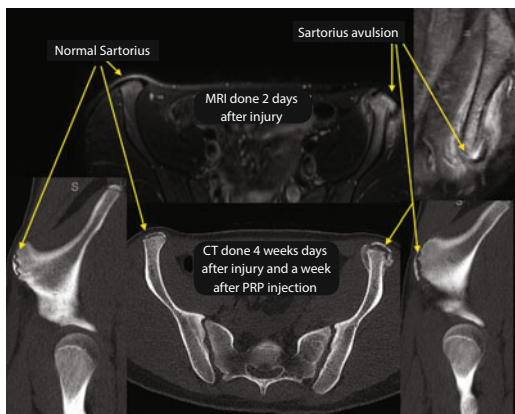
MRI demonstrating avulsion of the sartorius muscle from its origin on the anterior superior iliac spine (ASIS, top images). CT images comparing a normal sartorius origin on the ASIS (bottom left) and a sartorius avulsion (bottom right).
